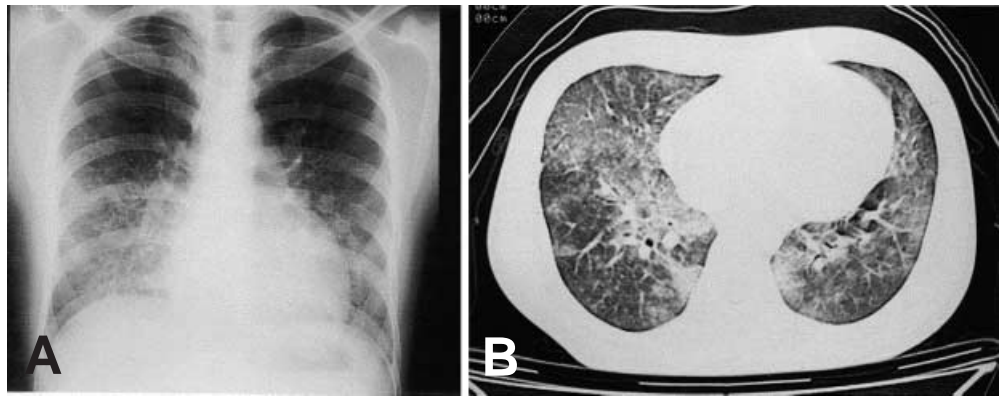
A Chest radiography and B computed tomography on day 9 after admission
